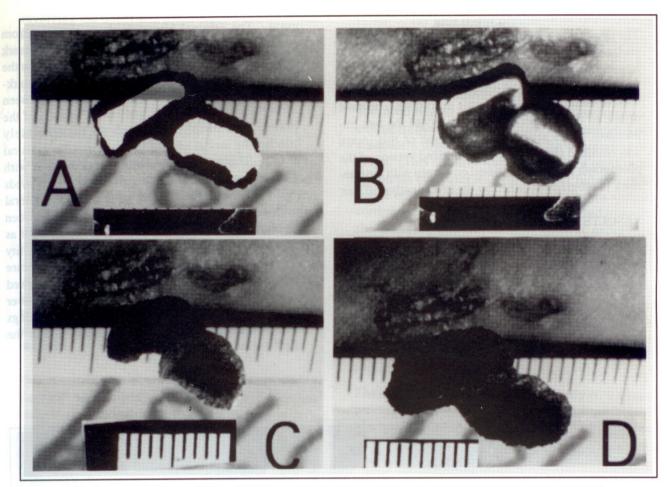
Computerized superimposition of tooth registrations onto original bitemark photograph: (a) radiographic technique, (b) photocopier technique, and (c and d) inking technique. Note the scale correspondence in each case.
